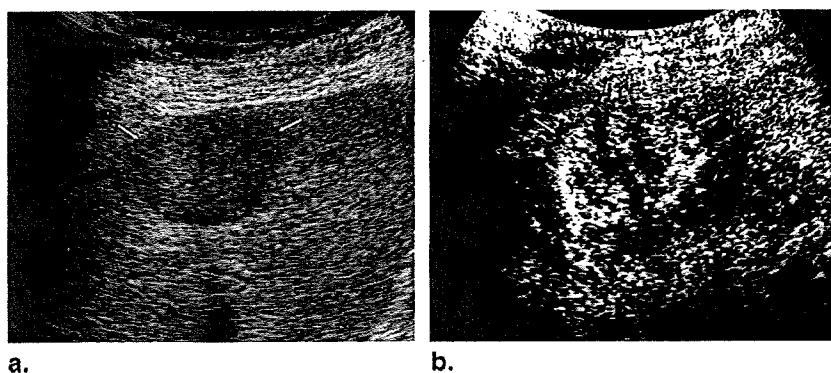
A 65-year-old man with metastatic colon cancer (*arrows*). (a) Intercostal B-mode ultrasound shows hypoechoic mass (*arrows*). (b) In the arterial phase, lesion (*arrows*) shows marginal vascularity.
